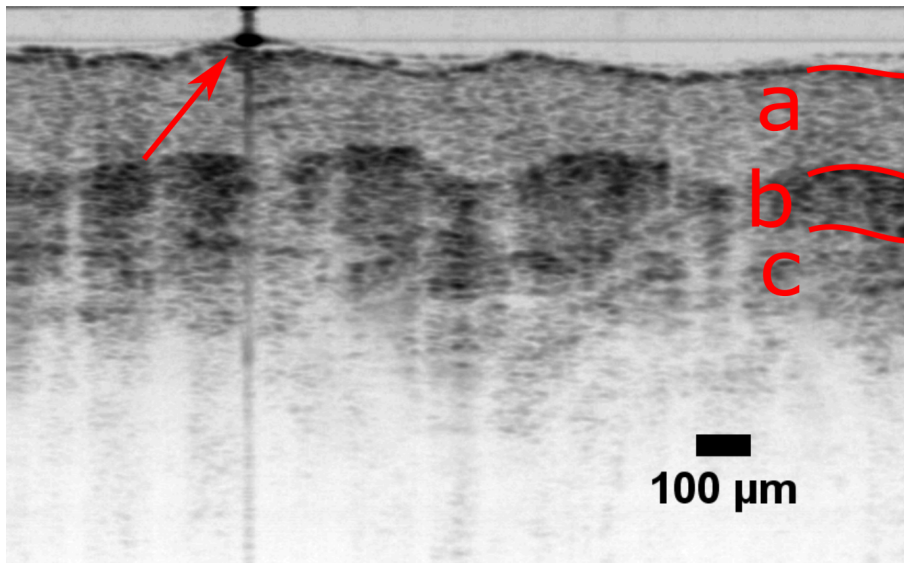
Ventral side of the finger, ultrasound gel has been applied to the surface in order to reduce the surface reflection, average of 80 B-scans. Note that this image has a different scale than the others as it was captured with a different scanning protocol. Skin layers are labeled a) Stratum corneum, the uppermost part of the epidermis, b) Stratum Granulosum, also part of the Epidermis and c) Beginning of the dermis. The arrow marks an artifact that arises from highly reflecting spots of ultrasound gel.
